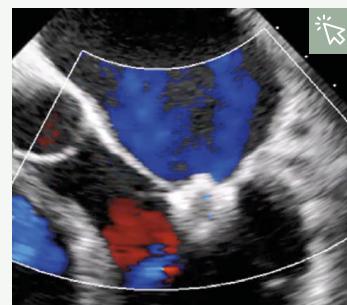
Final result on transoesophageal echocardiogram after placement of the PASCAL and PASCAL Ace implants.²⁷
